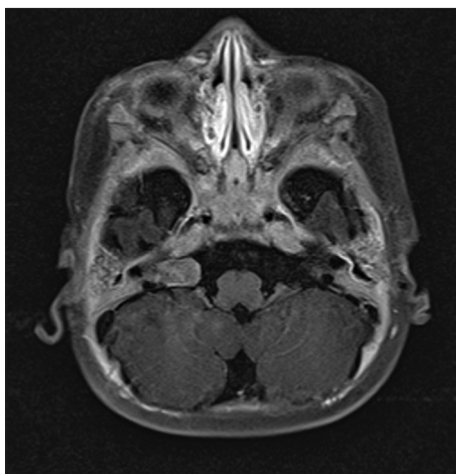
First magnetic resonance imaging of patient diagnosed as Rt cerebellopontine angle vestibulocochlear schwannoma due to internal auditory canal extension
